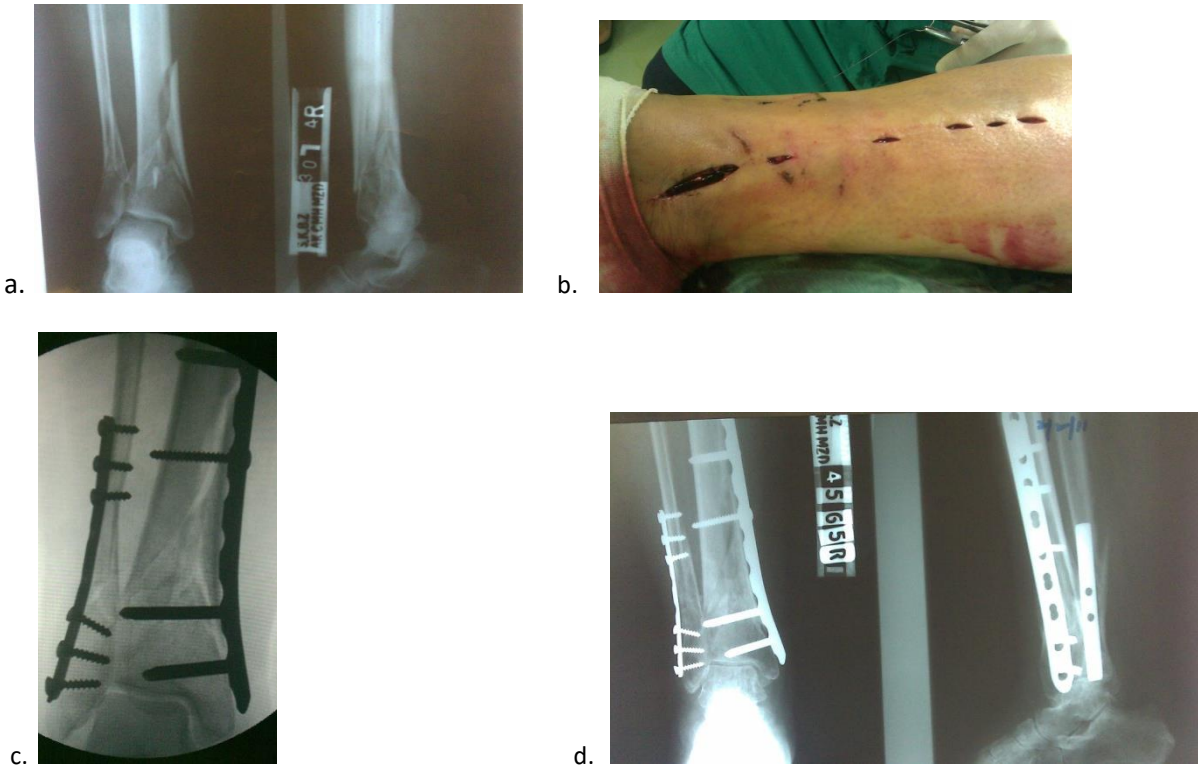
(a) Type A3 distal tibial fracture with distal fibular fracture. (b) Small foot-prints visible on skin with good radiological alignment after MIPO. Note 1/3rd tubular plate fixation of fibular fracture and 4.5mm narrow LCP on tibia. (c) Union is visible on X-rays at 14 weeks.
